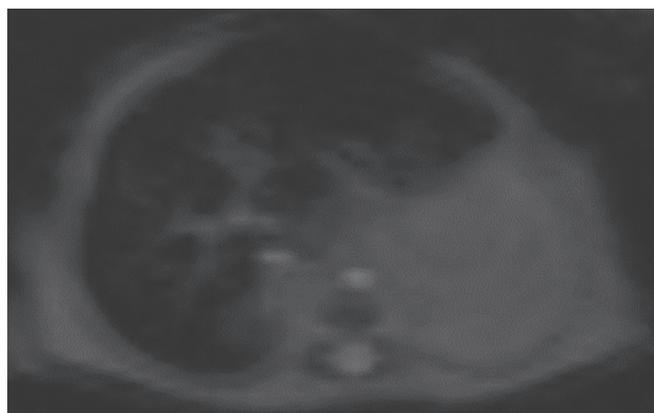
(Image 1): Magnetic resonance imaging of the abdomen on day 3 of life shows moderate-to-severe iron load in the liver with mild pancreatic iron overload. Liver iron time to echo (TE) 2.4 ms. The TE is the time between the delivery of the radiofrequency pulse and the receipt of the echo signal
